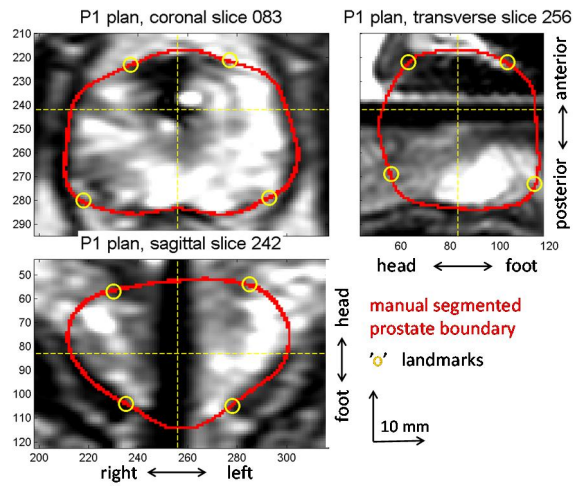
T2-weighted planning image for patient P1. Red contour shows manual segmentation and yellow 'o' label the landmarks.
